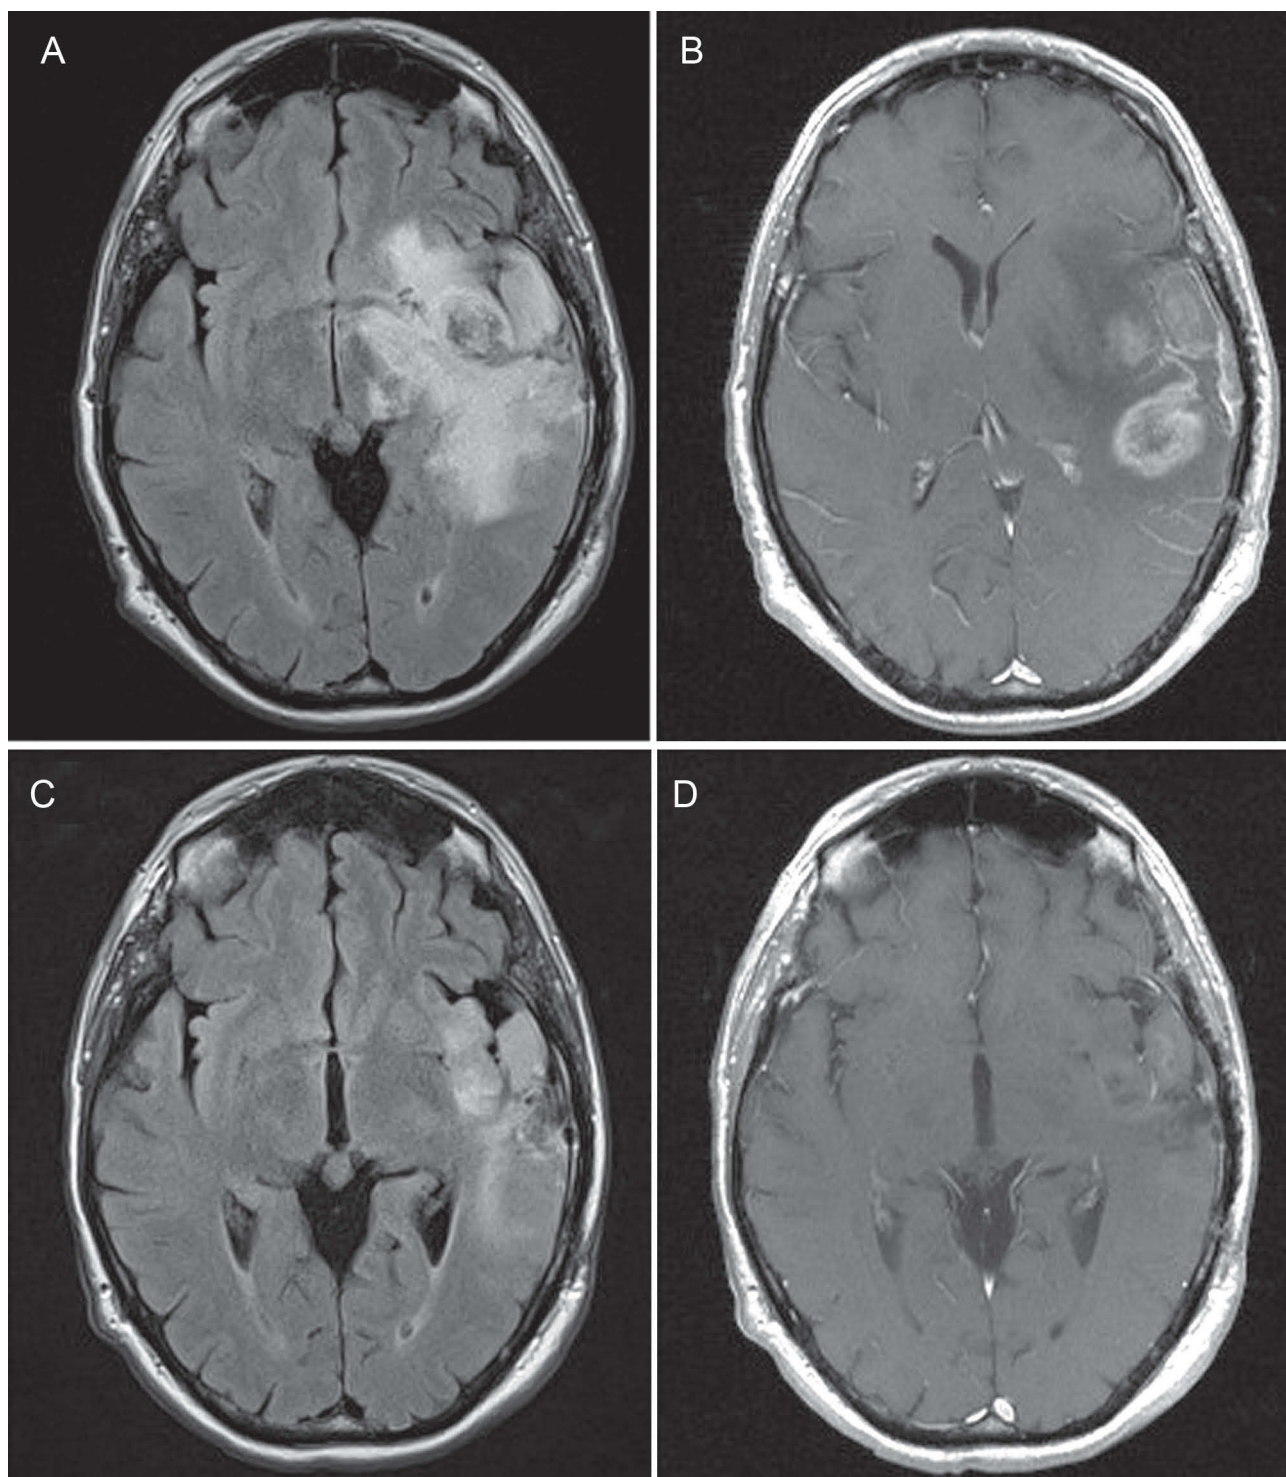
Magnetic resonance images of patient 3. Images A and B correspond to FLAIR and T1 sequences obtained three weeks after the patient completed treatment with chemoradiation therapy and after presenting a worsening of language skills. Images C and D correspond to the same sequences after two cycles of bevacizumab. It is possible to observe a considerable reduction in the vasogenic oedema, the mass effect and a reduction in the size of contrast uptake in the tumour.
